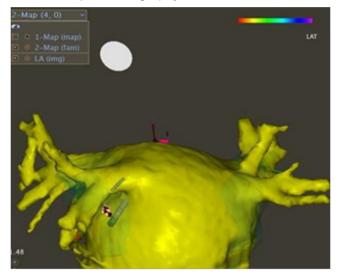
After merging the computed tomography with the electroanatomical map, catheter ablation can be performed using only the CT image.
